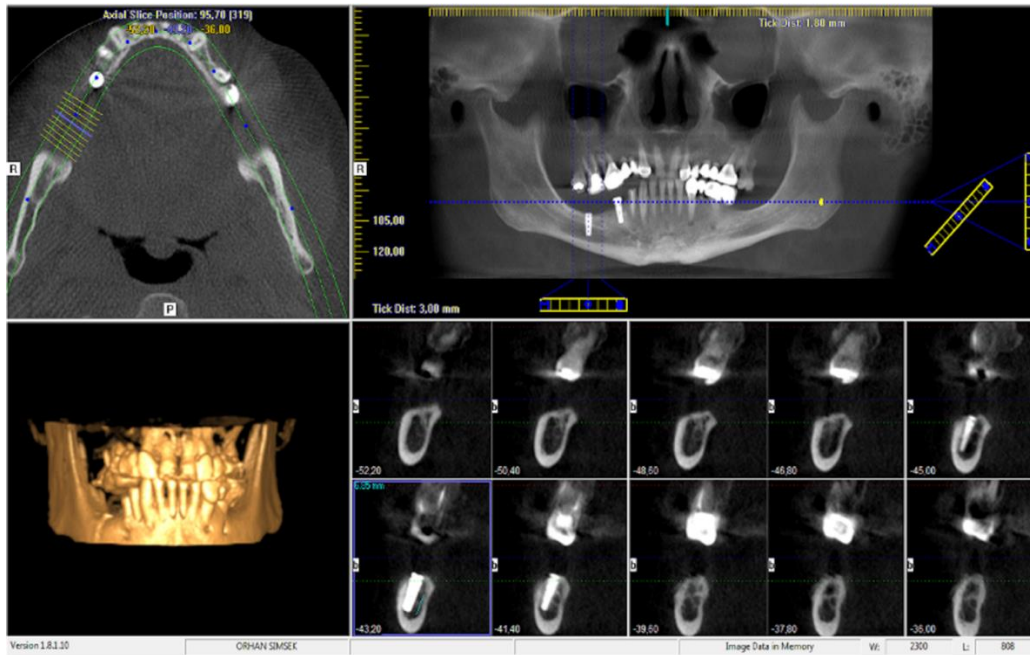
CT axial view showed vertical gain and panoramic view of the patient implant superimposition on mandibular canal.
